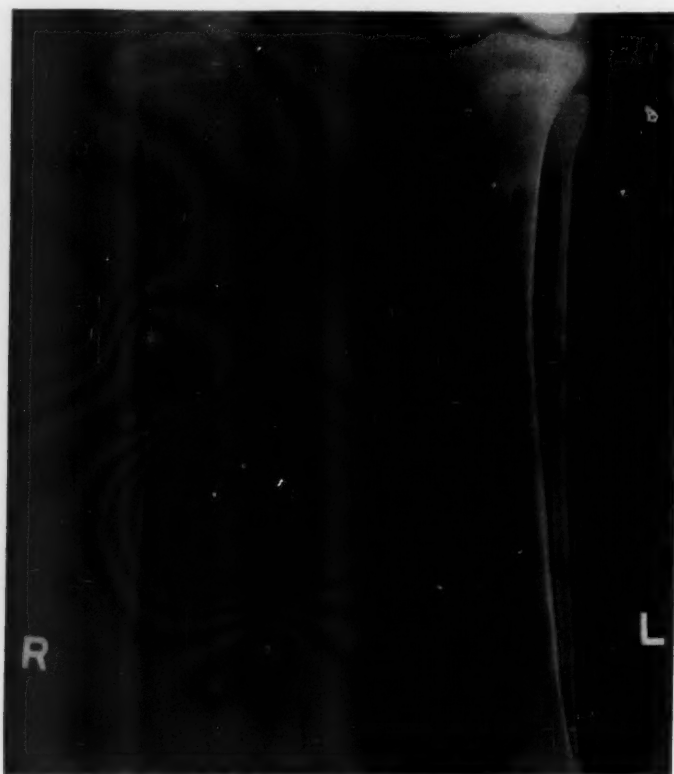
Roentgenogram of right and left legs showing cystic changes in the upper third of both tibiae and right fibula.
